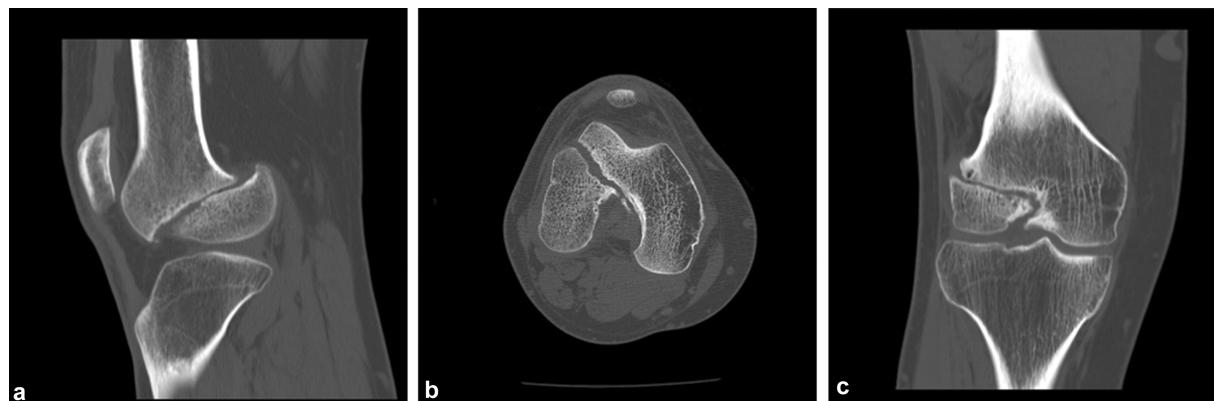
Sagittal, axial, and coronal CT scans.
